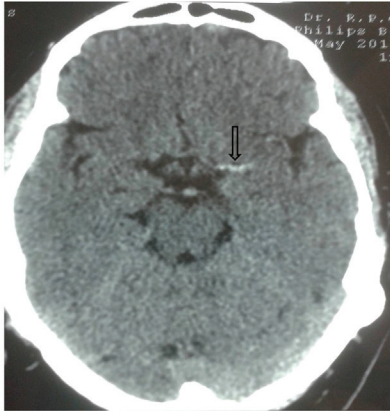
Hyperdense MCA sign. Noncontrast axial CT scan of the brain showing hyperattenuation of the left middle cerebral artery (arrow)
